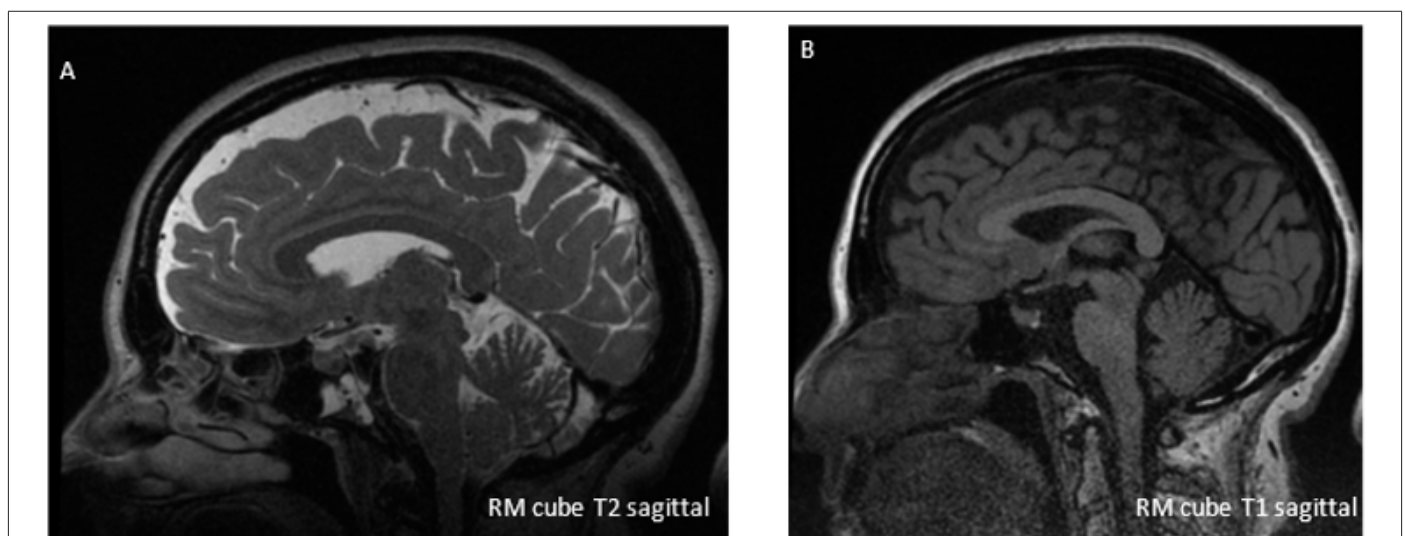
Lesion in the clivus at brain MRI Scan (Figure A: T2 MRI; Figure B: T1 MRI):
